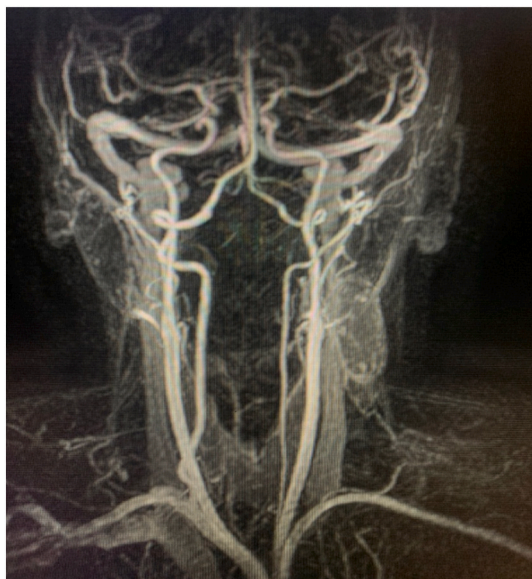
MRI angiography revealed feeding vessels mainly from the branches of the external carotid artery.
